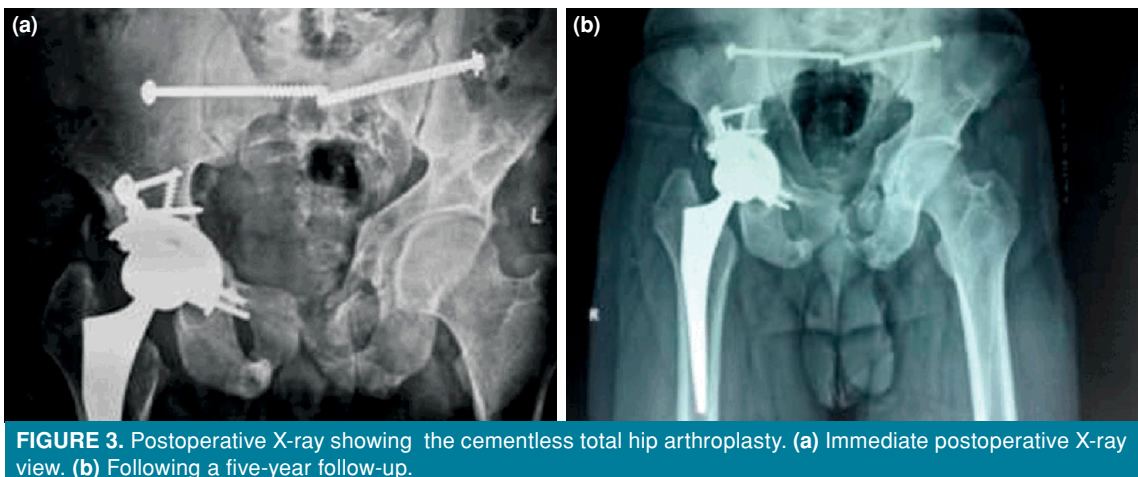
Postoperative X-ray showing the cementless total hip arthroplasty. (a) Immediate postoperative X-ray view. (b) Following a five-year follow-up.
